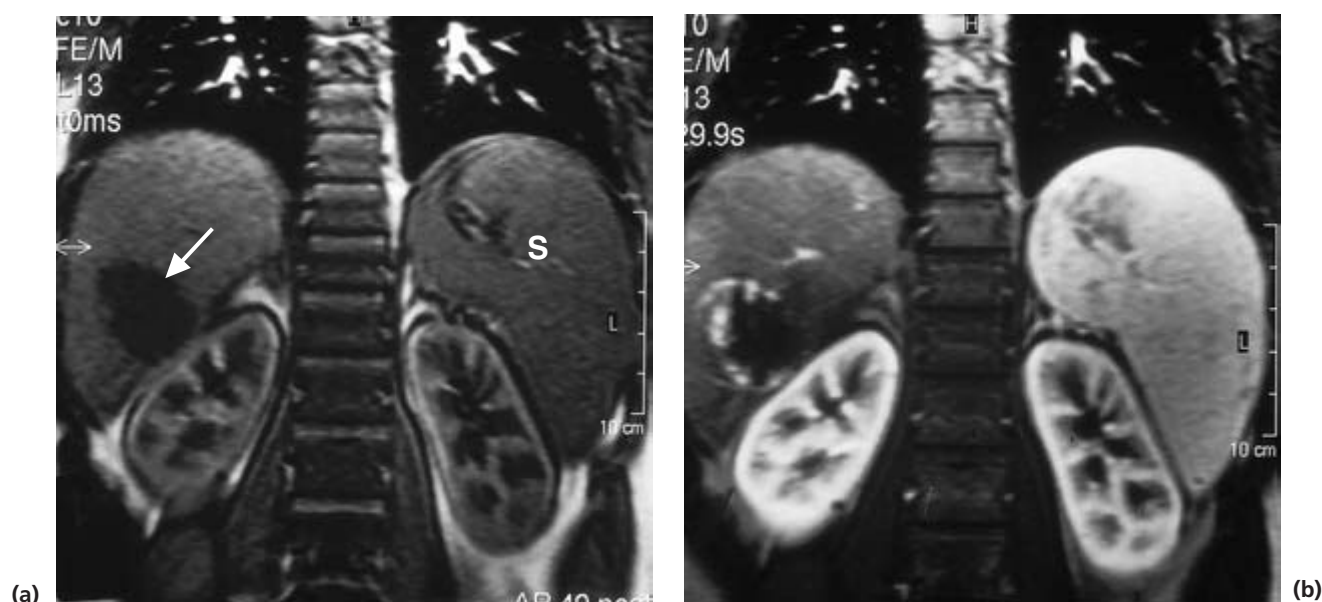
MRI of hepatic haemangioma. (a) T₁-weighted scan showing a typical low intensity lesion in the right lobe (arrow). (b) There is bright high intensity infilling at the periphery after gadolinium enhancement. Note incidental splenomegaly (S).
